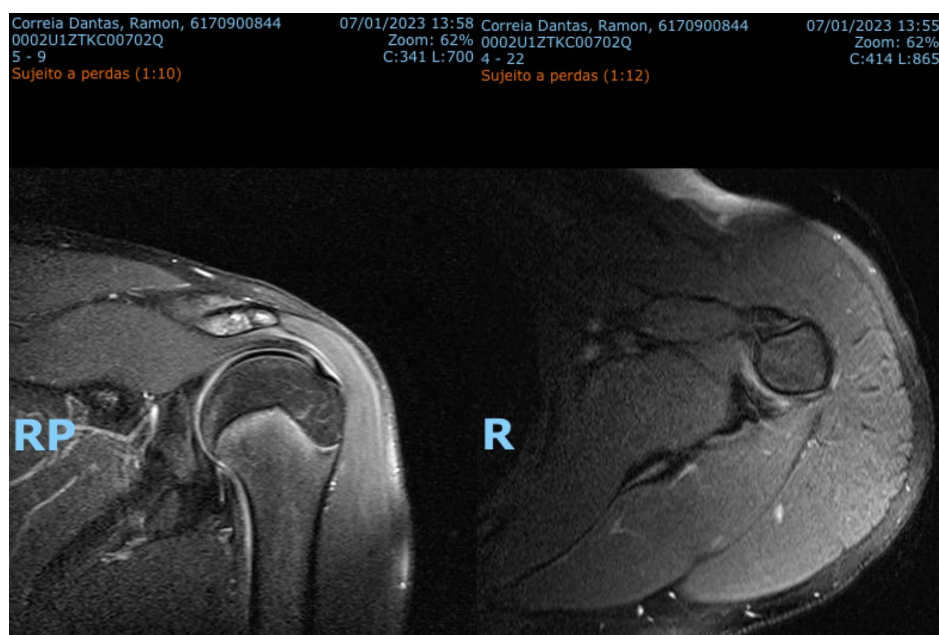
Post-treatment MRI images of the patient
